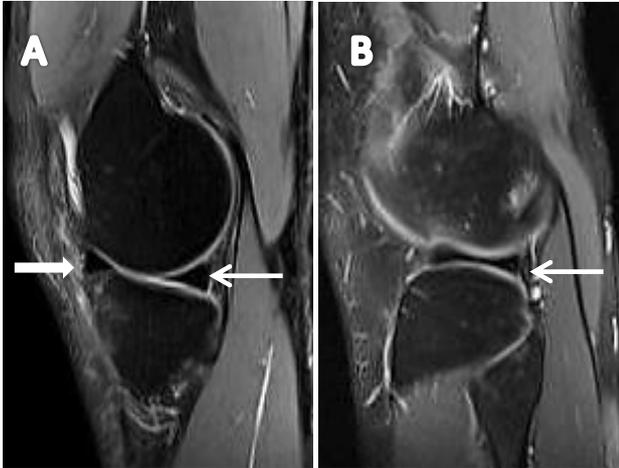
Normal MRI appearance of the menisci in a 30-year-old male. Sagittal T2-weighted FSE fat-suppressed image (A) and (B) shows the typical bow-tie configuration of the menisci. (A) Medial meniscus: The posterior horn (thin arrow) is larger than the anterior horn (thick arrow). (B) Lateral meniscus: shows the typical bow tie appearance of body of lateral meniscus (arrow). Both the horns are similar in shape and size.
